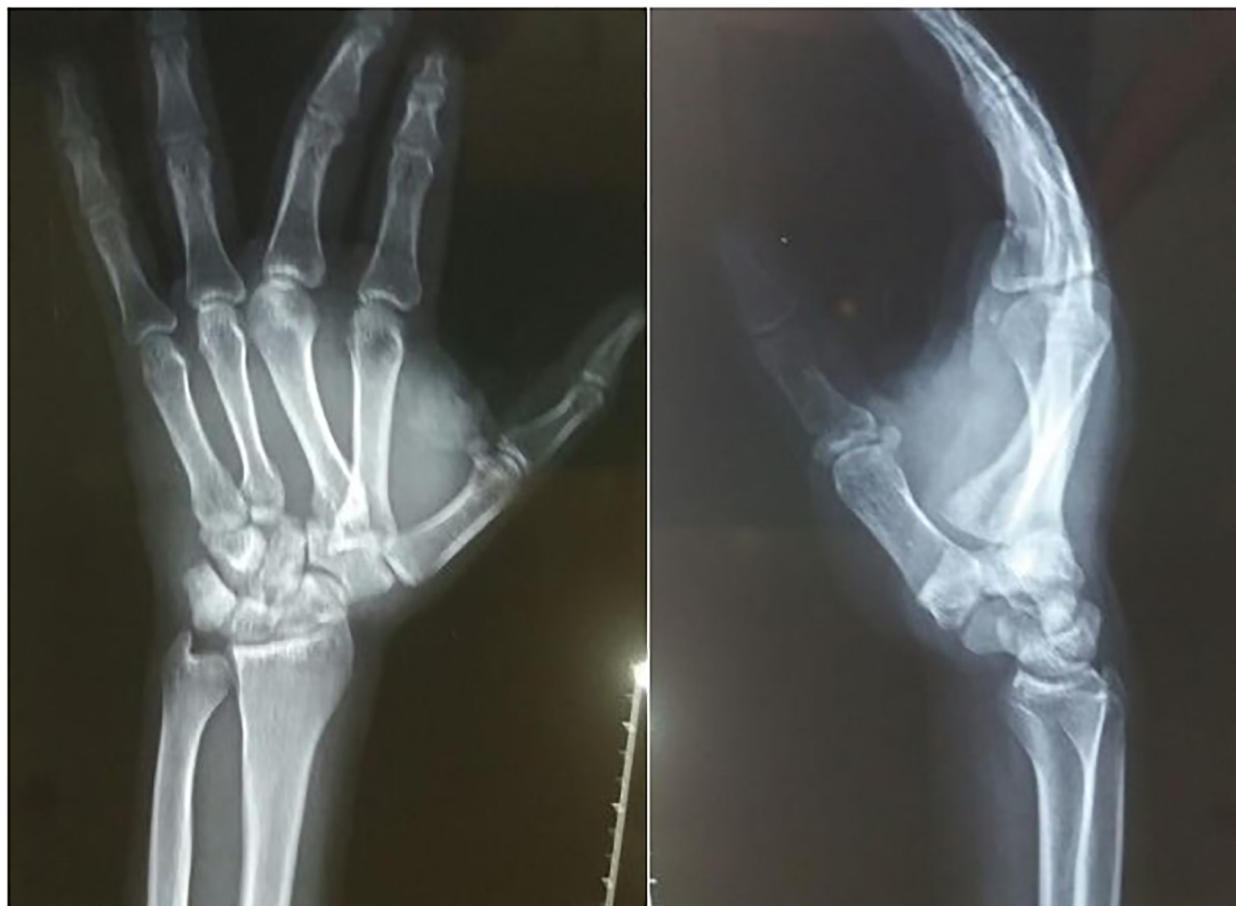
X-rays showing divergent dislocation of 2nd and 3rd CMC joint (dorsal displacement of 2nd and palmar displacement of 3rd CMC joint).
